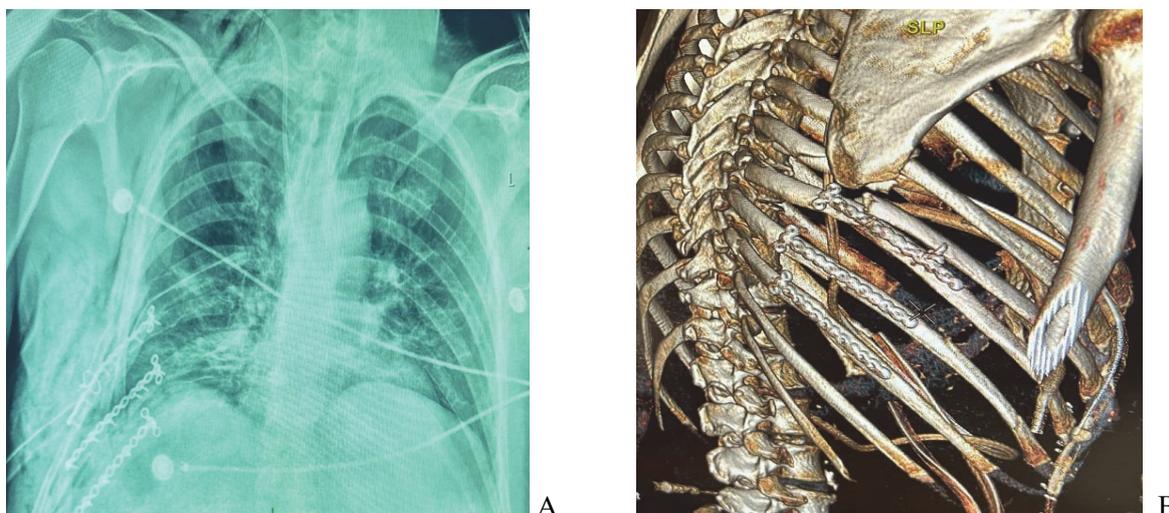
Control radiological studies in the postoperative period: A – chest organs X-ray on the 1st day after surgical treatment: the bone fragments of the ribs position is satisfactory, the lungs are expanded, there is no free air and gas; B – 3D modelling on the 5th day after surgical treatment: the position of the rib bone fragments is satisfactory.
